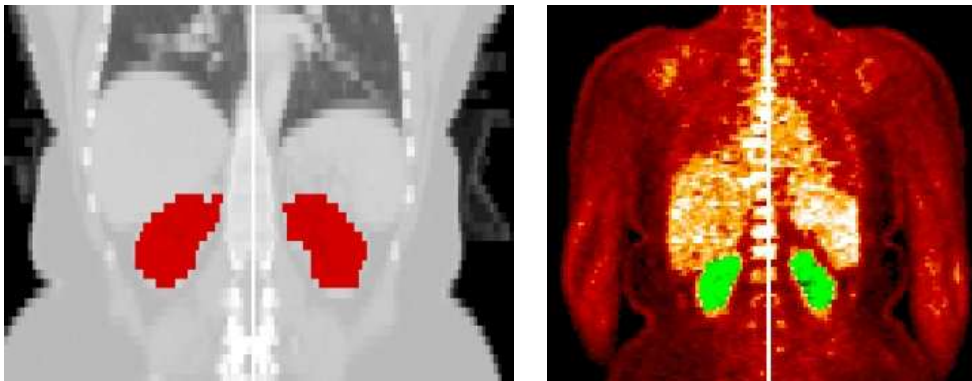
Symmetry plane (white vertical line) in a whole-body image and kidneys symmetry. Left: CT image; right: PET image
